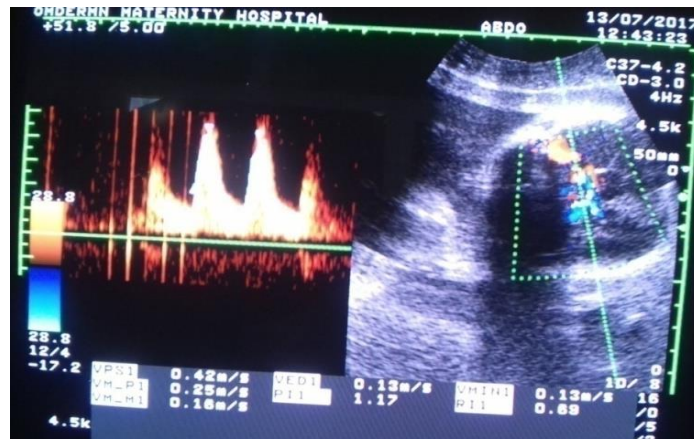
MCA Doppler ultrasonography of 29 year olds, para2, 31 weeks PE patient with 1.17 PI, 0.62 RI and 3.2 S/D ratio
